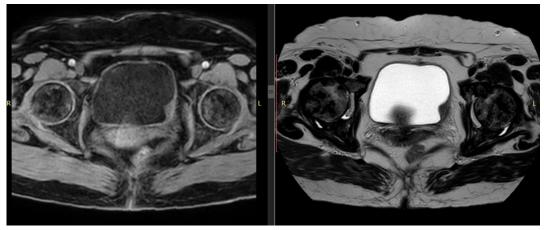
T1/T2weighted MRI images showing thickening of the left lateral wall of bladder.
